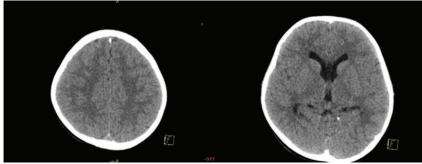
Axial CT Brain images show early falx cerebri and tentorium cerebelli calcifications.
